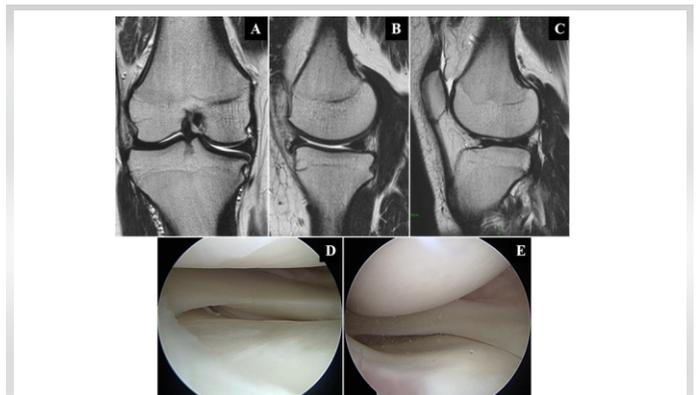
Pre-operative magnetic resonance imaging. (A) Coronal image, (B and C) sagittal images, (D and E) intra-articular arthroscopic findings at the lateral and medial compartments.
